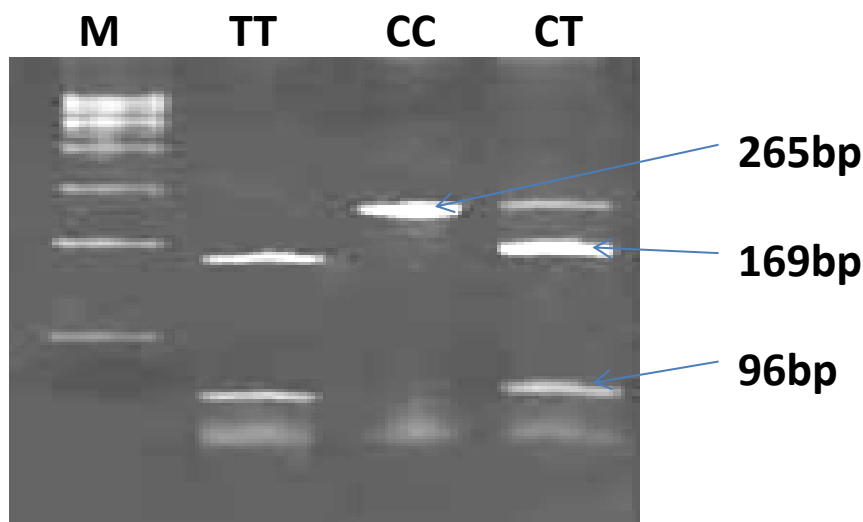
Figure No.-1: Representative gel picture of PTPN22 polymorphism. Lane M represents 50 bp molecular marker, Lane CC Wild type genotype, Lane CT heterozygous genotype and Lane TT variant genotype.
